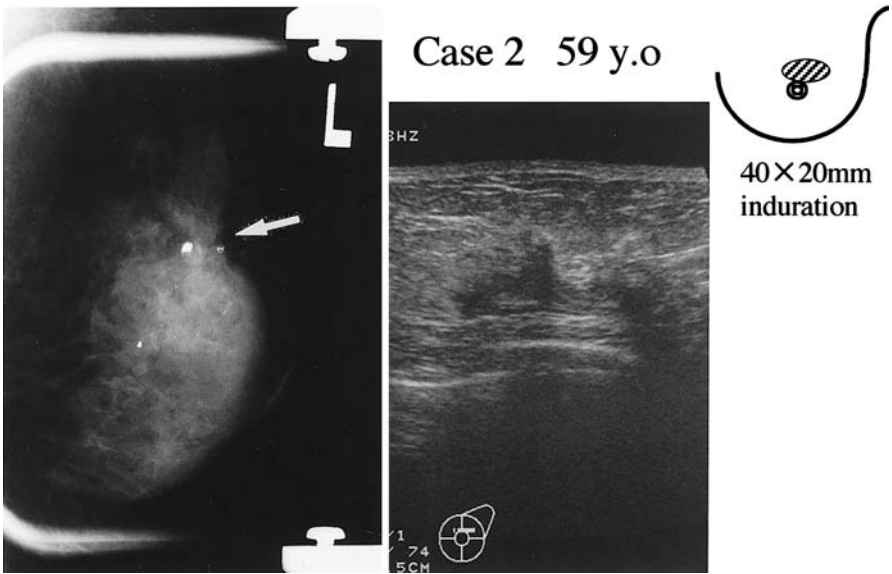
Focal distortion in MMG (arrow); irregularly shaped hypoechoic area by ultrasonography
